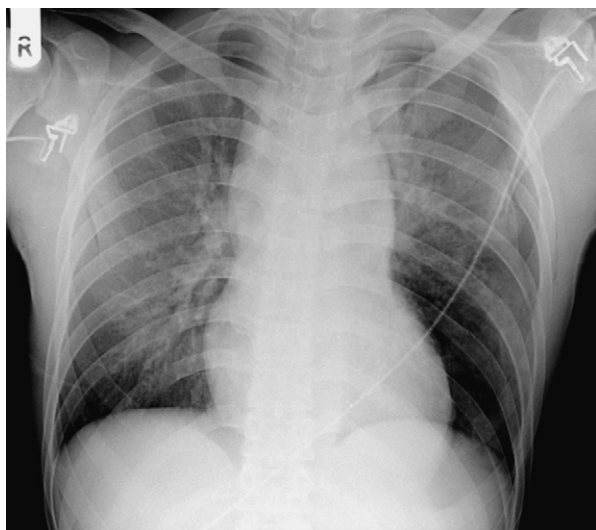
Supine chest X-ray in Emergency Department showing left haemothoraces, bilateral haemothoraces and fracture left 5th rib. Note the widened mediastinum and loss of aortic outline definition.
